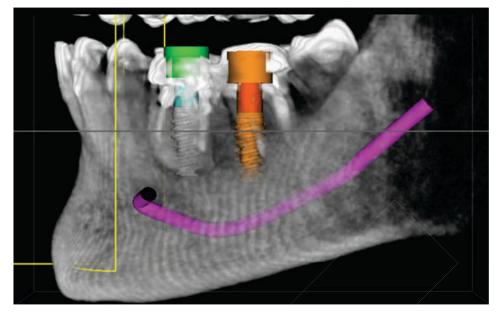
Virtual planning by means of CBCT.
